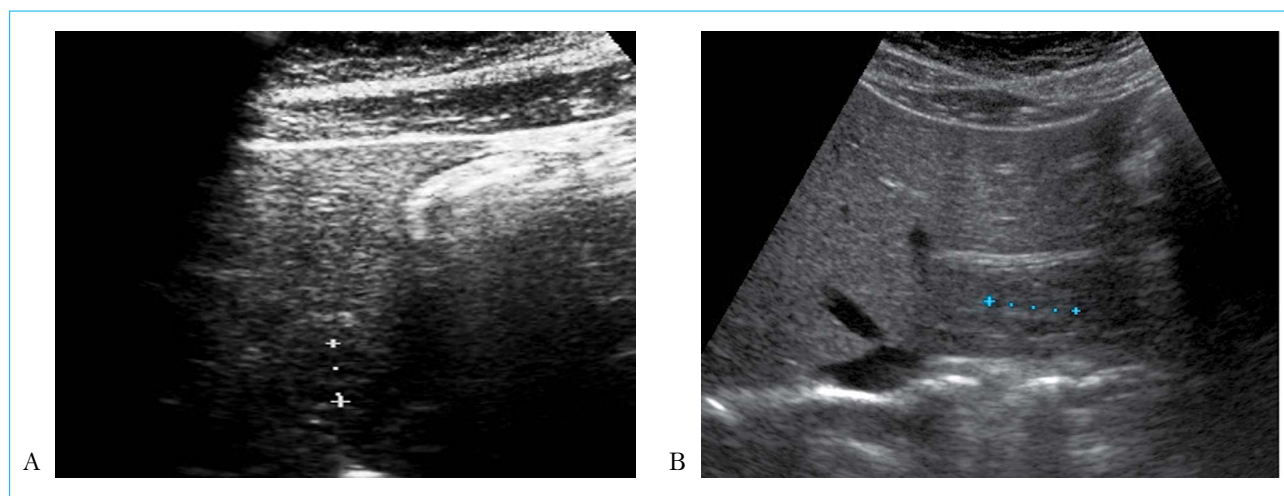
A — ultrasound picture of the FNH of the segment II of the liver during longitudinal scanning along the midline of the abdomen; B — during transverse scanning
